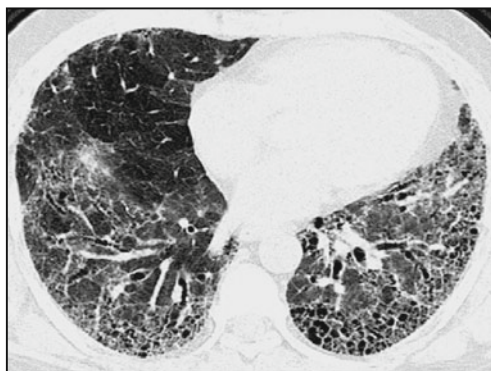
HRCT scan of chest showing bilateral interstitial ground glass appearance and fibrosis.
